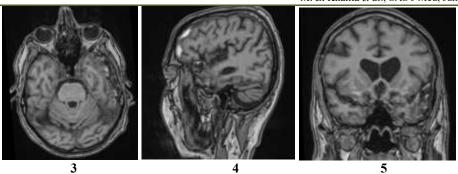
Brain MRI revealed cortico-subcortical foci in the left temporal lobe, involving the ipsilateral superior temporal gyrus (Brodmann area 22). This lesion contained porencephalic cavities and hemorrhagic sequelae consistent with a contusional origin
